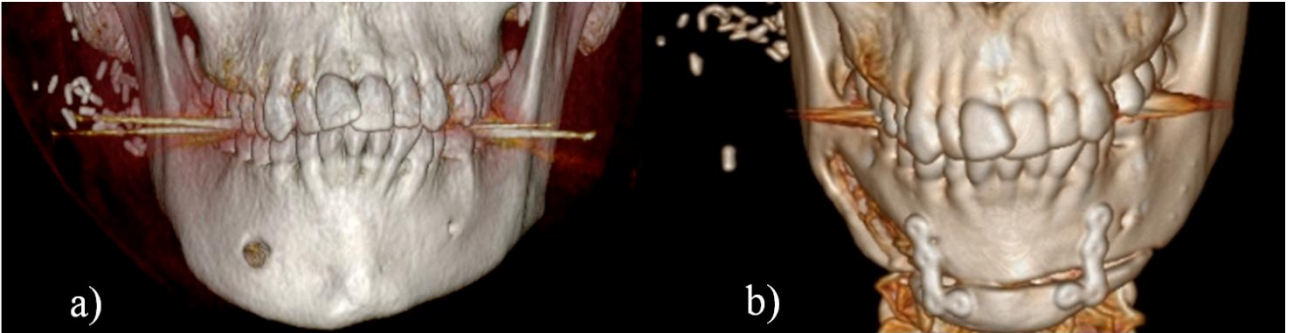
Three-dimensional CT reconstruction of the patient facial skeleton; a) before surgical treatment; b) after surgical treatment (study 4) [7].
